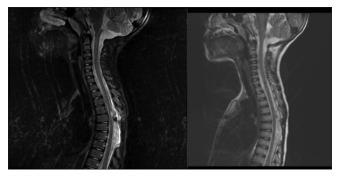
At 1-year follow-up, control magnetic resonance imaging of the spine showed no recurrence.
